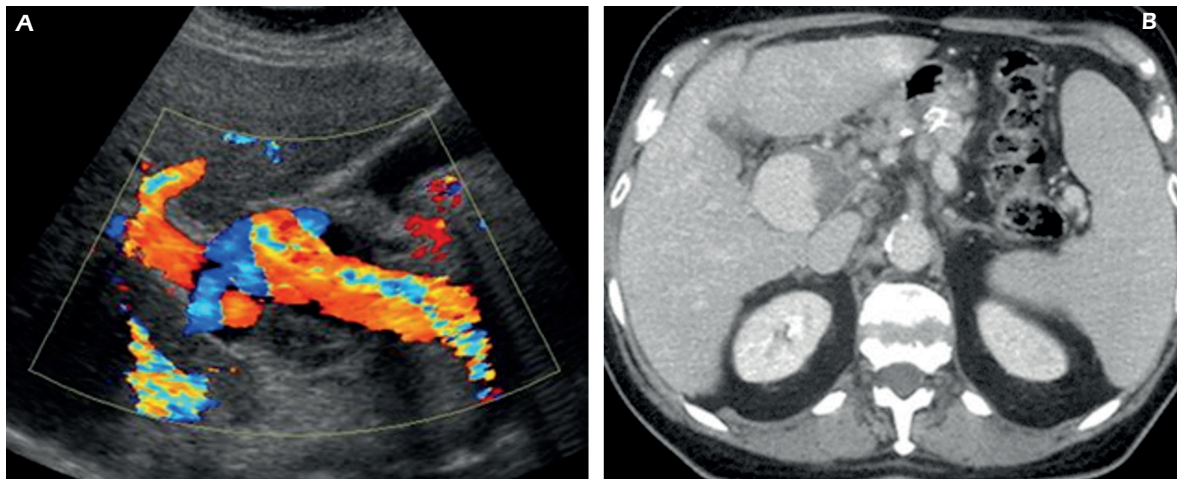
Portal vein aneurysm (PVA). A, Color Doppler Ultrasonography shows an aneurysm of the main portal vein with thrombotic mural apposition and turbulent flow within. B, Contrast-enhanced CT scan at the level of the hepatic hilum confirms the PVA with partial mural thrombosis.
